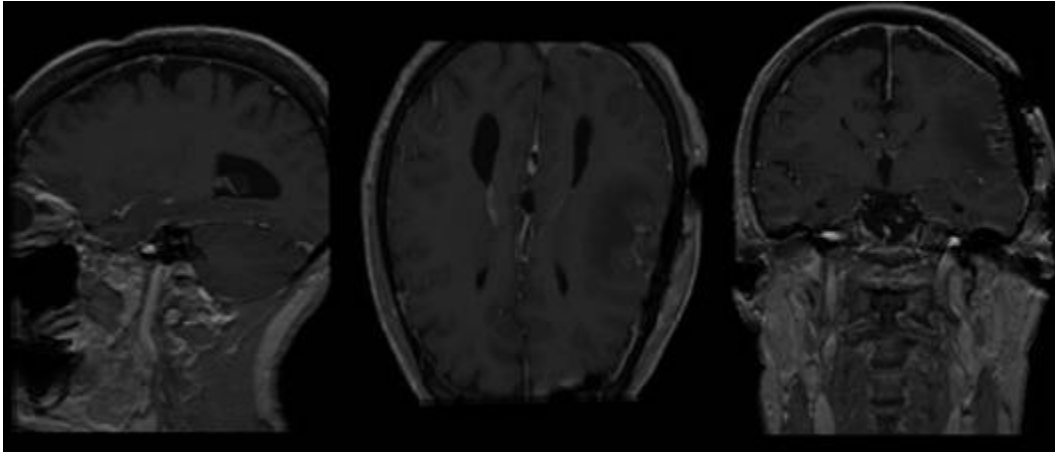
2D medical images (Sagittal, Axial, and Coronal) of Brainix MRI
